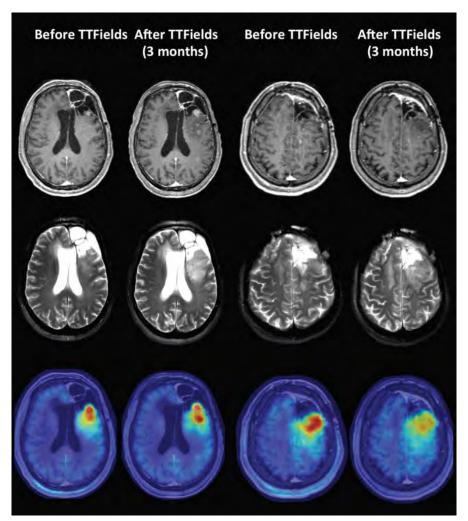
Heterogeneous metabolic response to TTFields treatment in a 51-year-old man with a recurrent left frontal glioblastoma progressing 4 months after completion of chemoradiation while on maintenance temozolomide. MRI (T1-Gad and T2) and AMT-PET/T1-Gad MR fusion images obtained at baseline and after 3 months of TTFields therapy suggested some progression. However, there were intratumoral differences in metabolic changes. Whereas the lower tumor portion showed an expansion of the area with contrast enhancement and high AMT uptake (first and second image panels), the upper tumor portion showed an interval decrease of AMT SUV from 4.9 to 3.8 (third and fourth panels).
